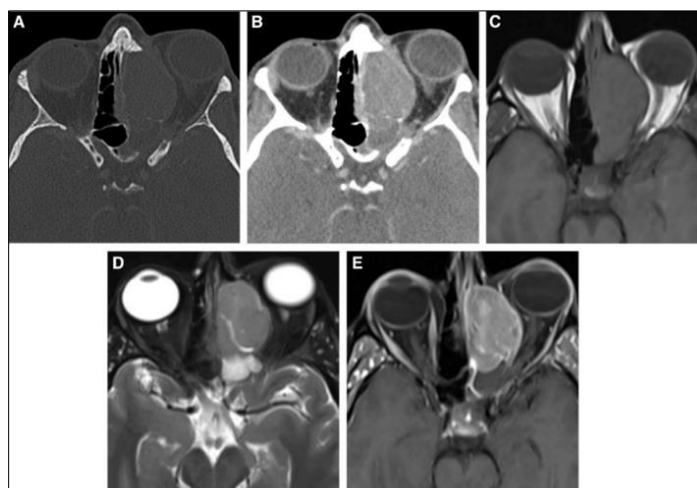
CT images of chronic granulomatous invasive fungal rhinosinusitis. (A) The bone window and (B) soft tissue window contrast-enhanced computed tomography show a mass filling extending into the left ethmoid sinus and the lamina papyracea. Proptosis is noted (left). (C) Axial T1 non-contrast MRI shows a mass isointense to muscle. (D) Axial T2 fat-saturated MRI shows a low-signal mass. (E) Axial T1 post-gadolinium fat-saturated MRI shows a homogeneously enhancing mass. The imaging appearance is similar to chronic invasive fungal rhinosinusitis, but in this case, the biopsy showed a poorly differentiated high-grade carcinoma⁵
